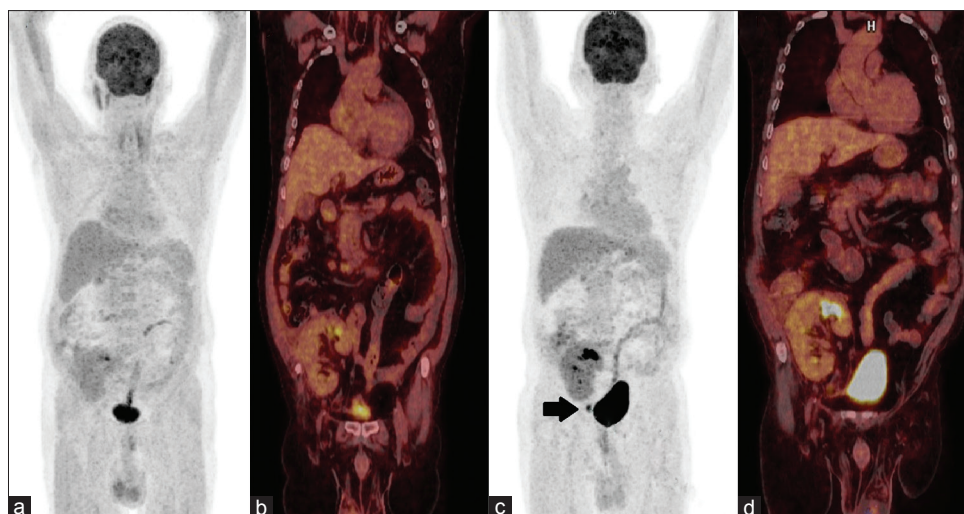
Interim (a) 18-fluorodeoxyglucose positron emission tomography-computed tomography maximum intensity projection reconstruction of computed tomography attenuation corrected image and (b) 18-fluorodeoxyglucose positron emission tomography-computed tomography (fused) coronal reconstruction image after four cycles of chemotherapy do not show any abnormal 18-fluorodeoxyglucose accumulation suggestive of a complete metabolic response to chemotherapy. Only holdup of tracer in calyx of transplanted kidney at the upper pole is seen. (c) 18-fluorodeoxyglucose positron emission tomography-computed tomography maximum intensity projection reconstruction and (d) 18-fluorodeoxyglucose positron emission tomography-computed tomography (fused) coronal reconstruction image after six cycles of chemotherapy show similar findings as in interim positron emission tomography-computed tomography except urine hold up in mid ureter (arrow)
